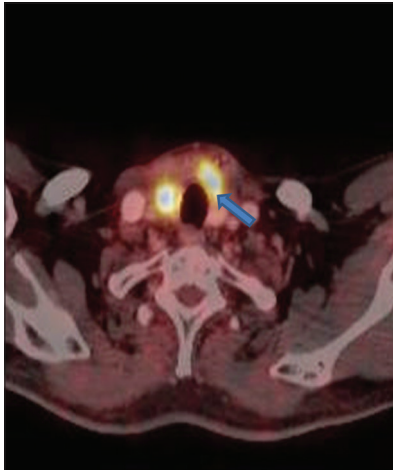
Axial PETCT shows high grade FDG (Fluorodeoxyglucose) avid nodules in right lobe and isthmus of thyroid gland (arrow)
